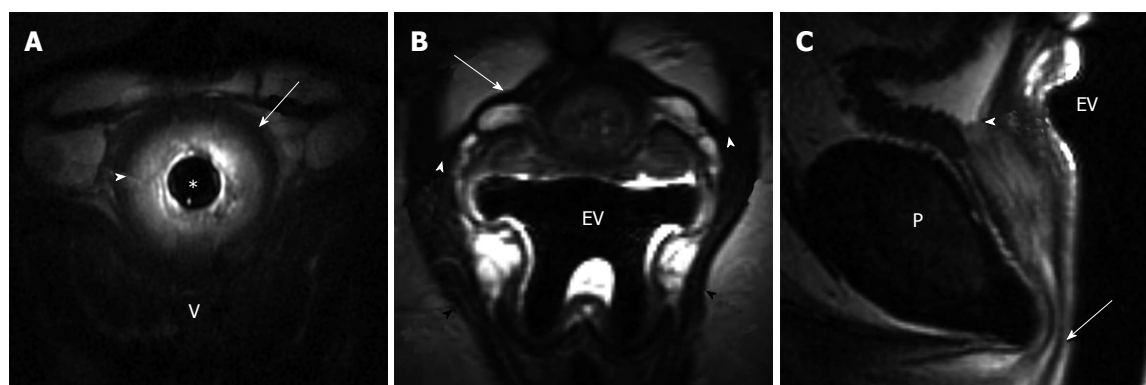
41-year-old woman post one vaginal delivery with episiotomy, body mass index: 46.7, with occasional stress urinary incontinence. A: Axial T2-weighted image of the mid urethra obtained with 14F endourethral MR coil (TR/TE 4816/68 ms) shows detailed depiction of the urethral sphincter with a hypointense outer layer of striated muscle (arrow) and inner hyperintense smooth muscle layer (arrowhead); B: Axial T2-weighted image at the mid urethra level obtained with endovaginal placement of MRInnervu coil (EV) (TR/TE 3000/92 ms) shows well-defined intact periurethral ligament (arrow) extending between the right and left puborectalis muscle (black arrowheads). Note symmetric, intact ligament attachment (white arrowheads); C: Sagittal T2-weighted image obtained with endovaginal placement of MRInnervu coil (EV) (TR/TE 4000/92 ms) shows normal resting position of the urethra, with distal end of urethral sphincter (arrow) at inferior pubis level (P). Note excellent coaptation of the mucosa at internal meatus/bladder neck level (arrowhead). V: Vagina.
